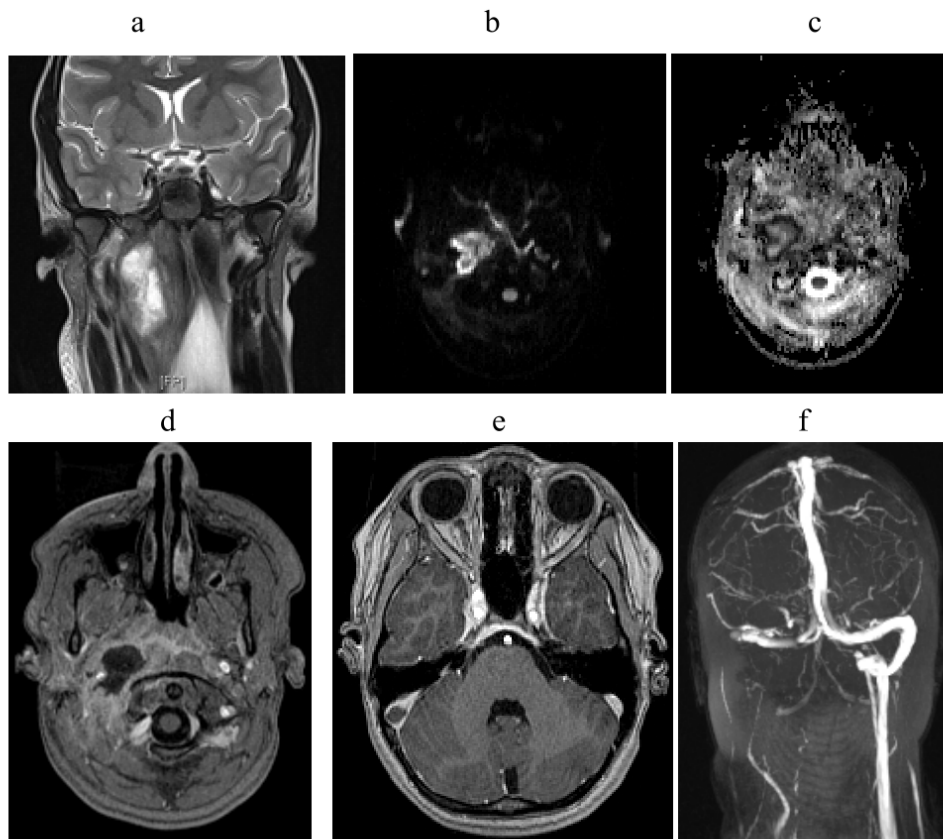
MRI on day 5 shows enlarged lymph node in right RPS (T2W) with restricted diffusion in the periphery (2b and 2c, DWI and ADC map). Post Gadolinium enhancement scan shows central necrosis and diffuse surrounding soft tissue enhancement/phlegmon (2d, GdT1W). There is non-occlusive thrombus in the right sigmoid sinus on the MRV which was acquired with Gd (2e, GdT1W). MRV also demonstrates lack of blood flow in the right sigmoid to jugular vein (2f).
